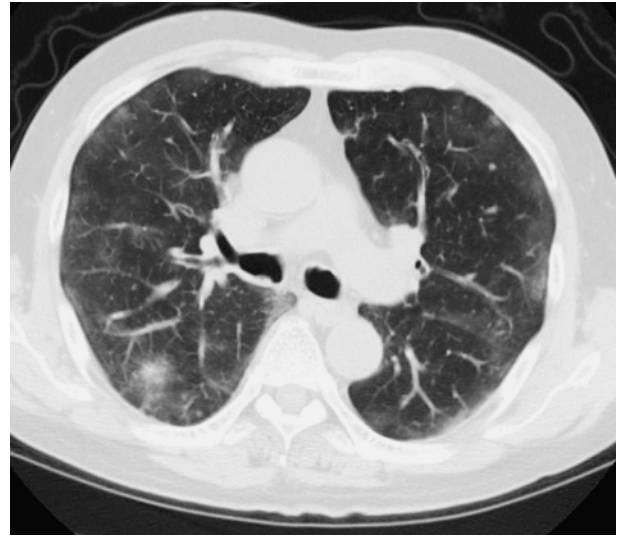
Chest computed tomography scan on admission showing small nodular shadows with diffuse, partially patchy, ground-glass opacities.
